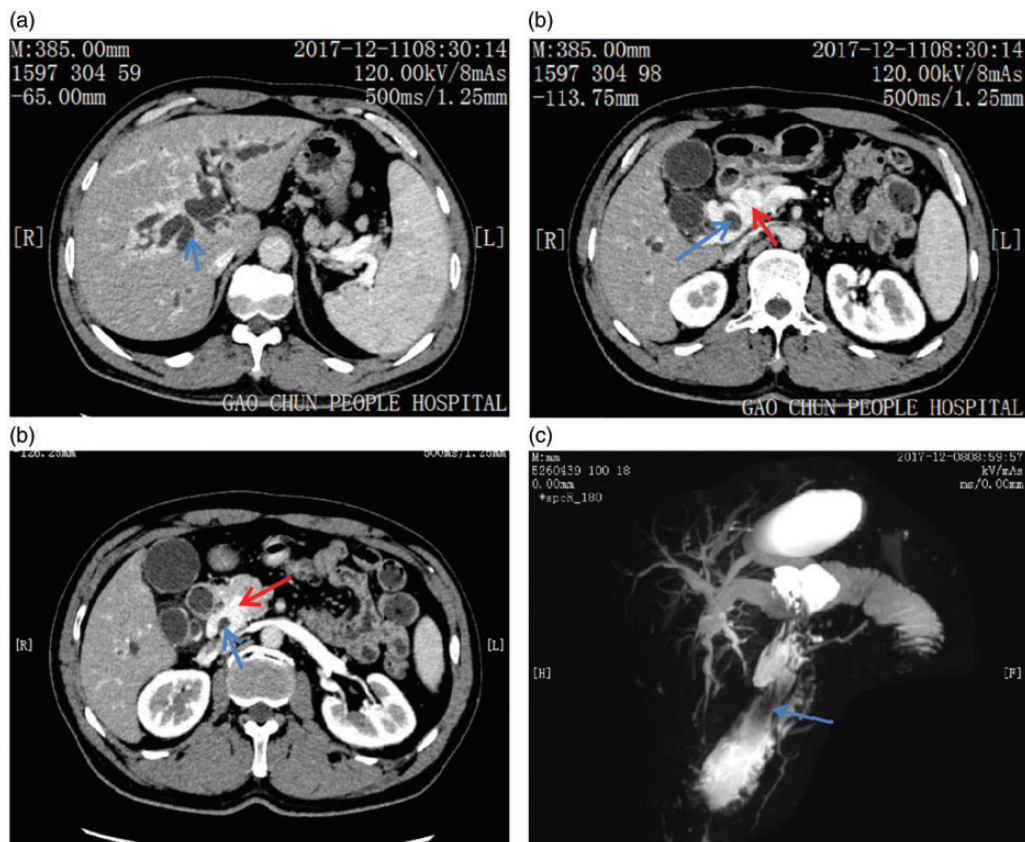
Computed tomography and magnetic resonance cholangiopancreatography images at the patient's first admission. Computed tomography showed significant dilation of (a, b) the intrahepatic bile duct and common bile duct (blue arrows) and (b, c) the collateral pathway of the portal vein (red arrows). (b, c) Additionally, the lower section of the common bile duct was compressed, deformed, and narrow with segmental upstream dilatation (blue arrows). (d) Magnetic resonance cholangiopancreatography showed that part of the intestine overlapped with the relatively narrow and smooth common bile duct (blue arrow).
